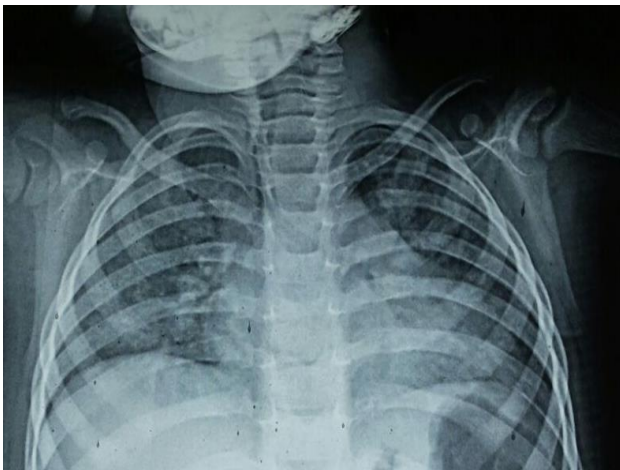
Chest X-ray AP view of two years old girl with no pleuroparenchymal disease.
